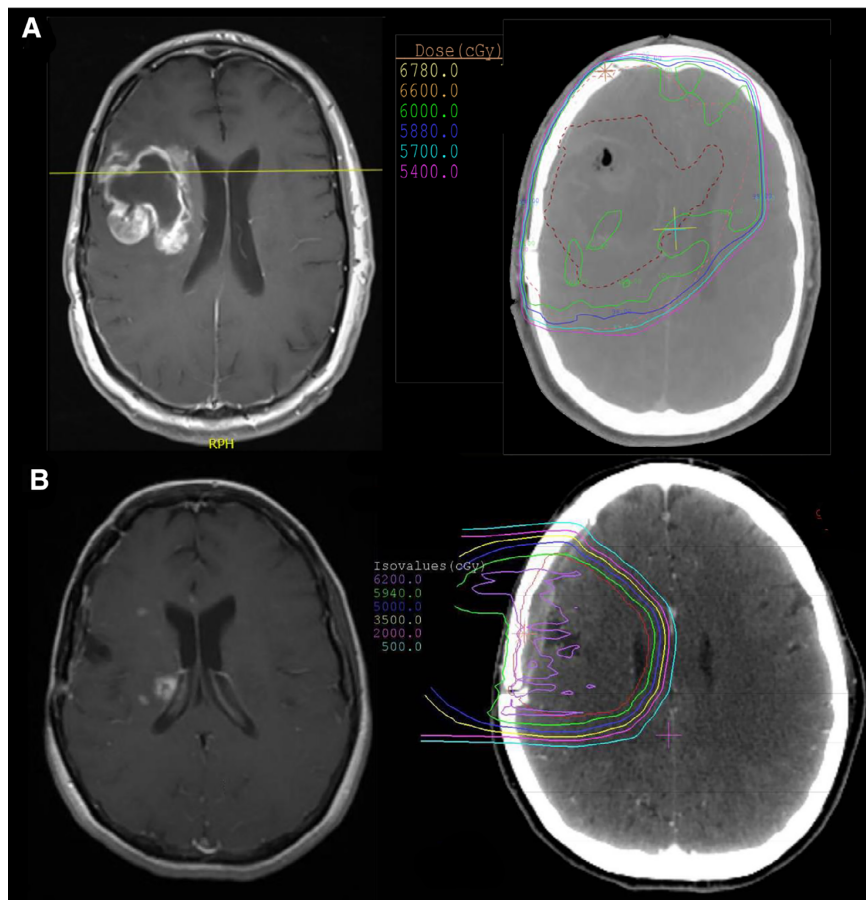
Typical observed radiographic features of treatment-induced brain tissue necrosis (TN) and pseudoprogression (PP). (A): Axial T1+ contrast magnetic resonance imaging (MRI) (left) showing a non-nodular focus of enhancement around the tumor resection cavity (RC) in the right frontal lobe, first manifesting at 3 months after radiotherapy (RT), consistent with PP. Corresponding radiotherapy dose distribution overlay on axial computed tomography (right) demonstrates the main radiation field encompassing the RC and surrounding brain parenchyma (60 Gy; green line). (B): T1+ contrast MRI (left) showing multiple small nodular foci of enhancement located medially to the RC in the right frontal region with involvement of the periventricular white matter, manifesting at 11 months after RT, consistent with TN. RT dose distribution overlay on axial computed tomography (right) demonstrates prior exposure of these regions of interest to the main radiation field (59.4 Gy; green line).
